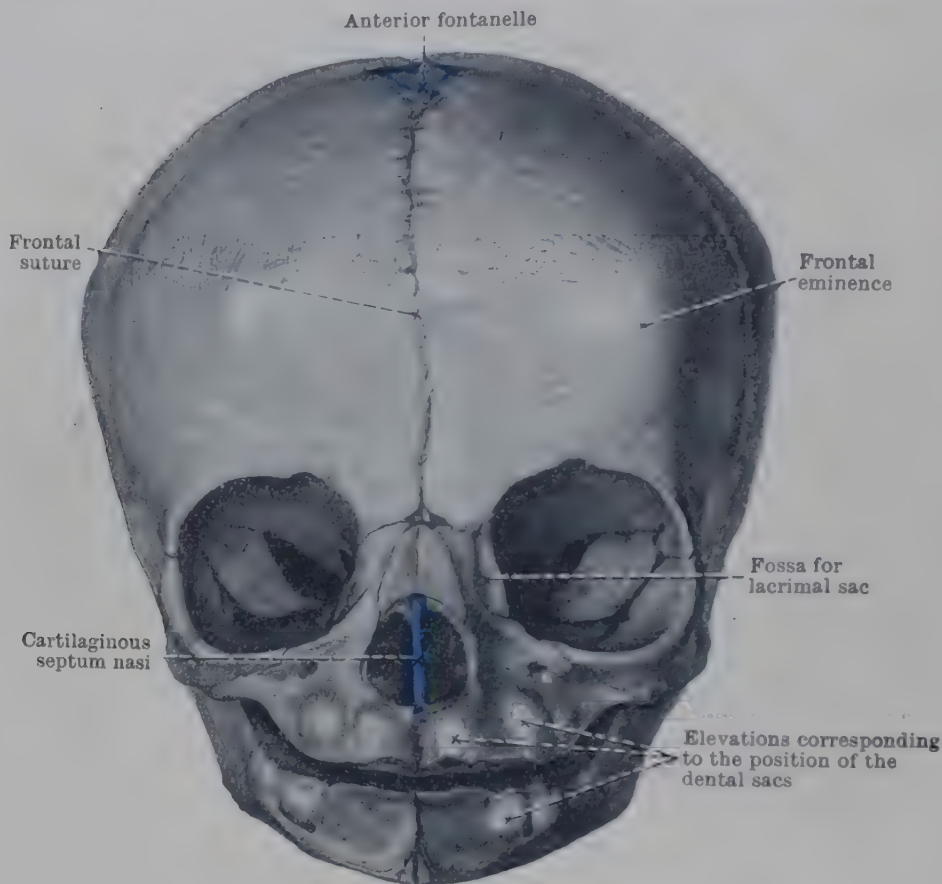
FRONTAL ASPECT OF SKULL AT BIRTH. (Cf. Pl. V, Fig. 1, p. 150.)
